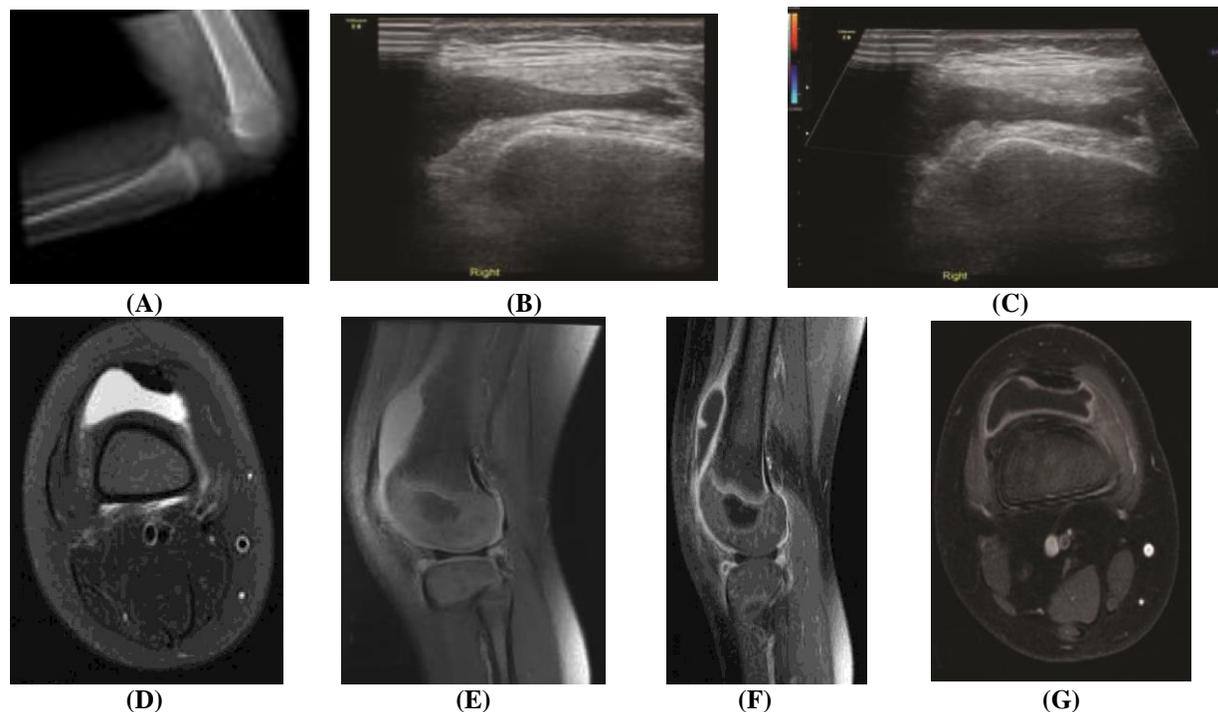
3 years old girl with history of sickle cell disease complaining of right Knee swelling fever and limitation of movement. (A) Radiography of right knee joint lateral views show no detectable abnormality.(B&C) Gray scale and colour Doppler high resolution US axial view respectively showing turbid suprapatellar fluid collection without any flow vascularity.
